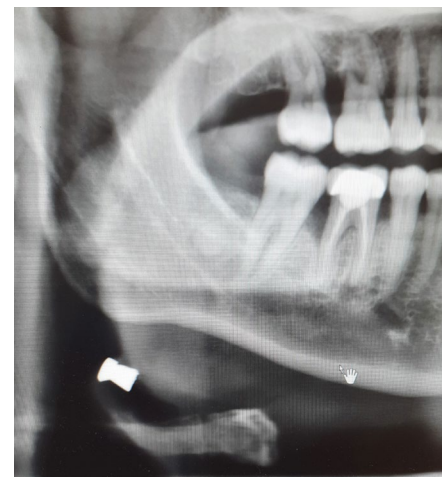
Radiograph showing a pellet in a patient's mandible
